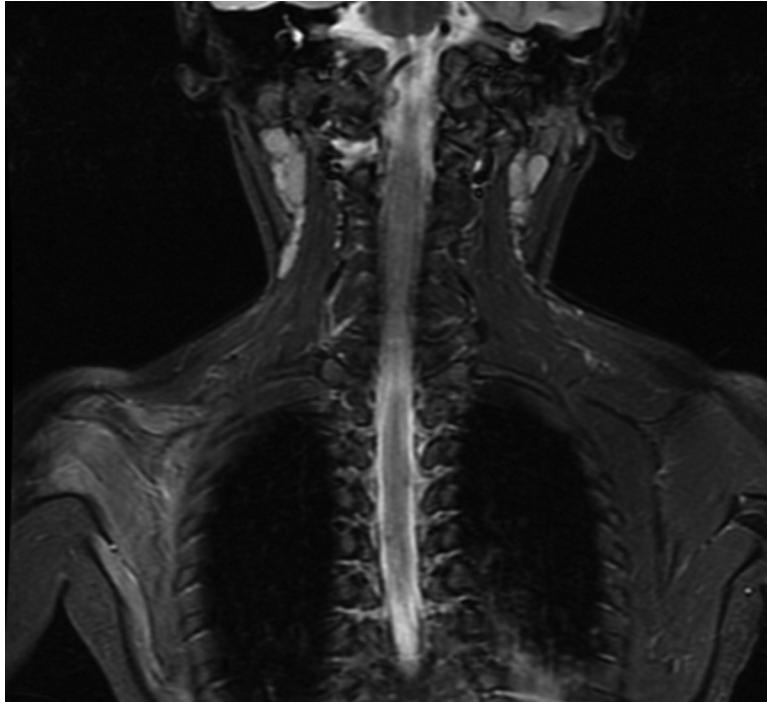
An MRI completed 3 months postinjury. Imaging revealed defused atrophy involving the musculature of the right shoulder girdle, an abnormal signal of the infraclavicular portion of the right BP, and a right proximal humeral physis T2 hyperintense signal suggestive of epiphyseal edema.
